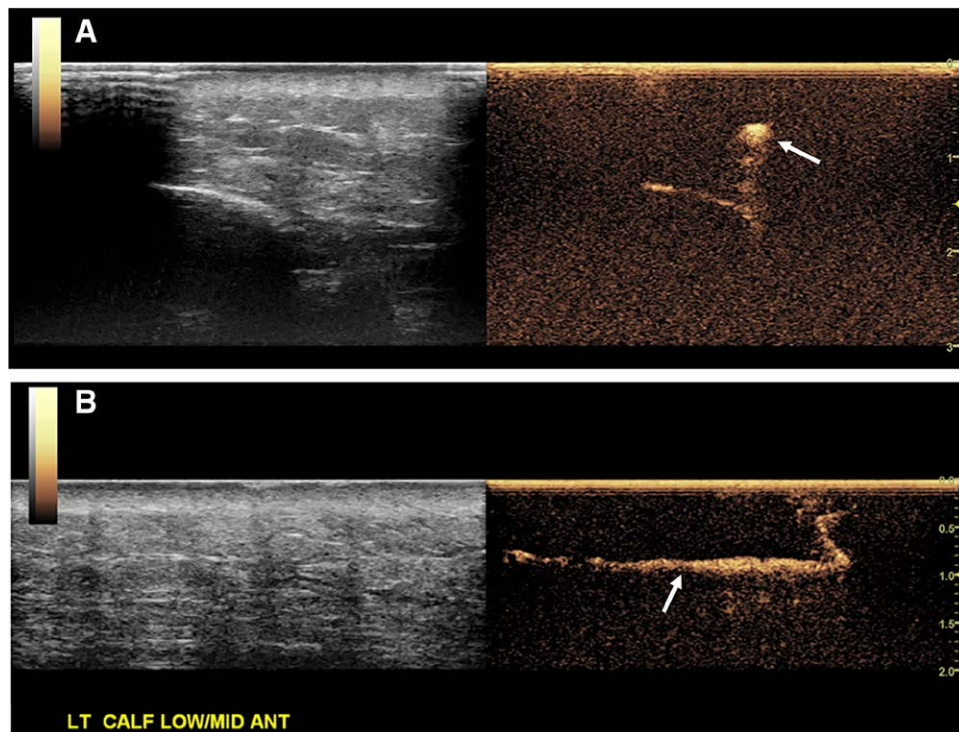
Dual display of B-mode and contrast-enhanced ultrasound screens. After intradermal injection of microbubbles, their uptake by a lymphatic vessel (arrows) is shown in the transverse (A) and the longitudinal (B) planes. Sometimes, the lymphatic vessels branch into numerous smaller branches, and the most robust channels are usually marked on the skin at the discretion of the radiologist.
